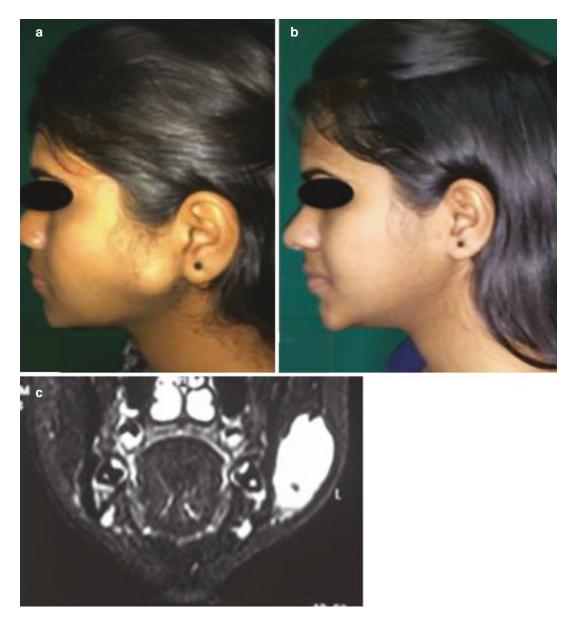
Venous malformation-Left cheek (a) before sclerotherapy, (b) after sclerotherapy, (c) pretreatment T2-weighted MRI image
